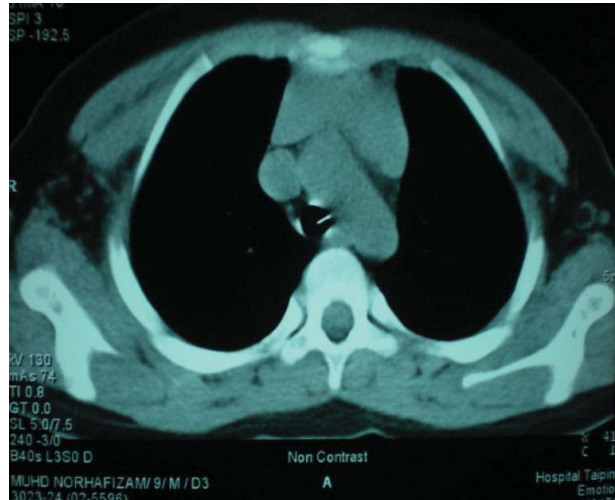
The CT scan image confirm the presence of the foreign body in the trachea at level of T1
